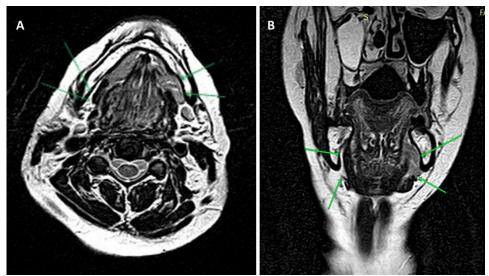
Axial and coronal T2-weighted MRI images demonstrate an empty submandibular fossa on the right side
